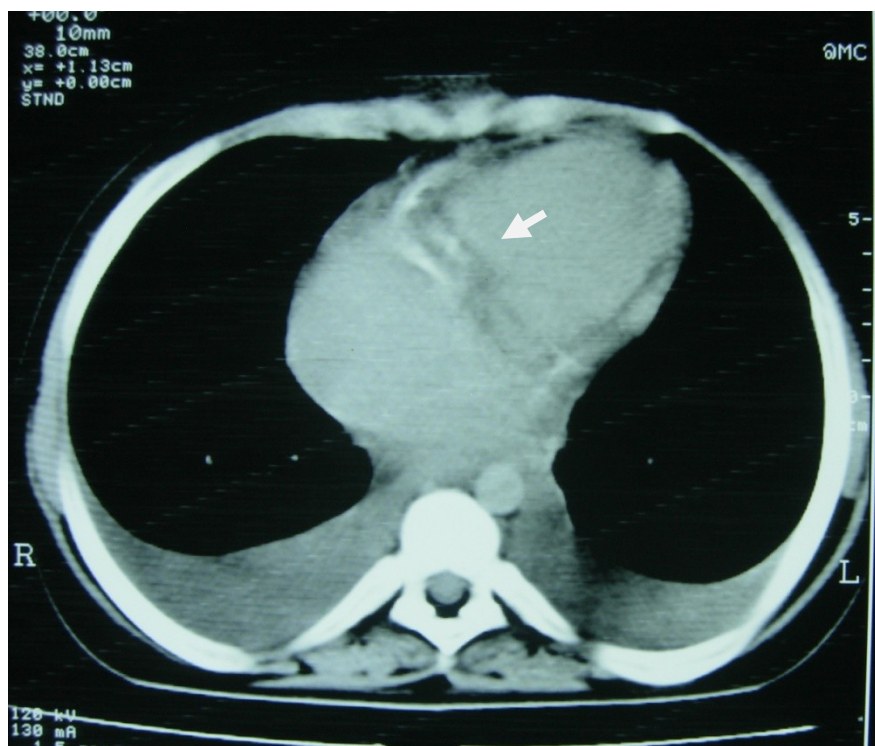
A Contrast enhanced CT chest showing thickened pericardium with Rt AV groove calcification in a patient with constrictive pericarditis. Bilateral pleural effusion is present.
